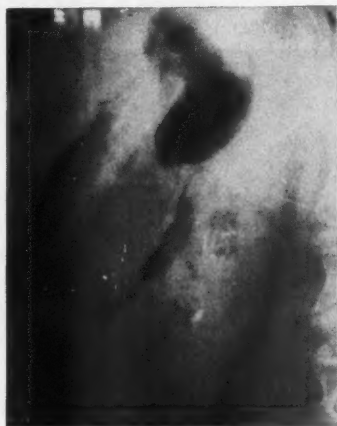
Feb. 11, 1955. Preoperative flat plate roentgenogram of abdomen showing gallbladder wall outlined by gas.
